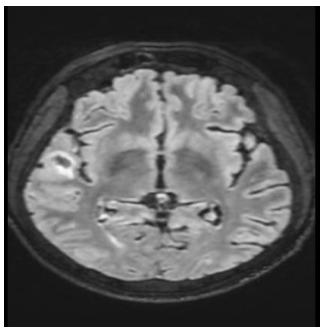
MRI T2 flair axial image shows hypointense area with surrounding edema and effacement of adjacent sulcal spaces in right anterior temporal lobe.
